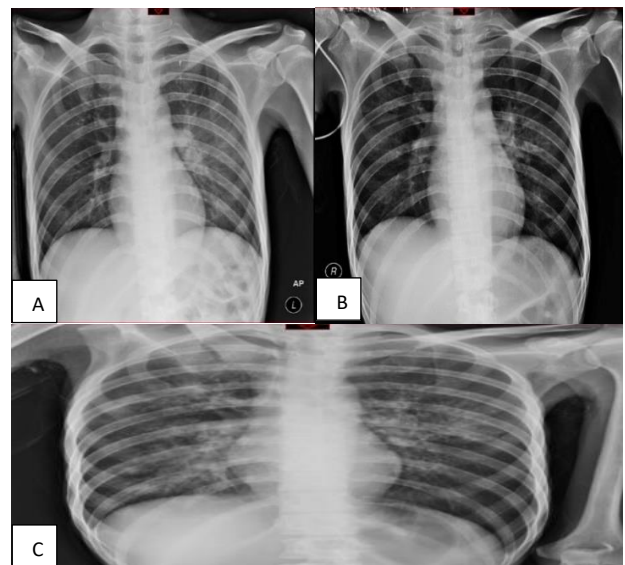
(A-C): Serial of chest X-ray.
